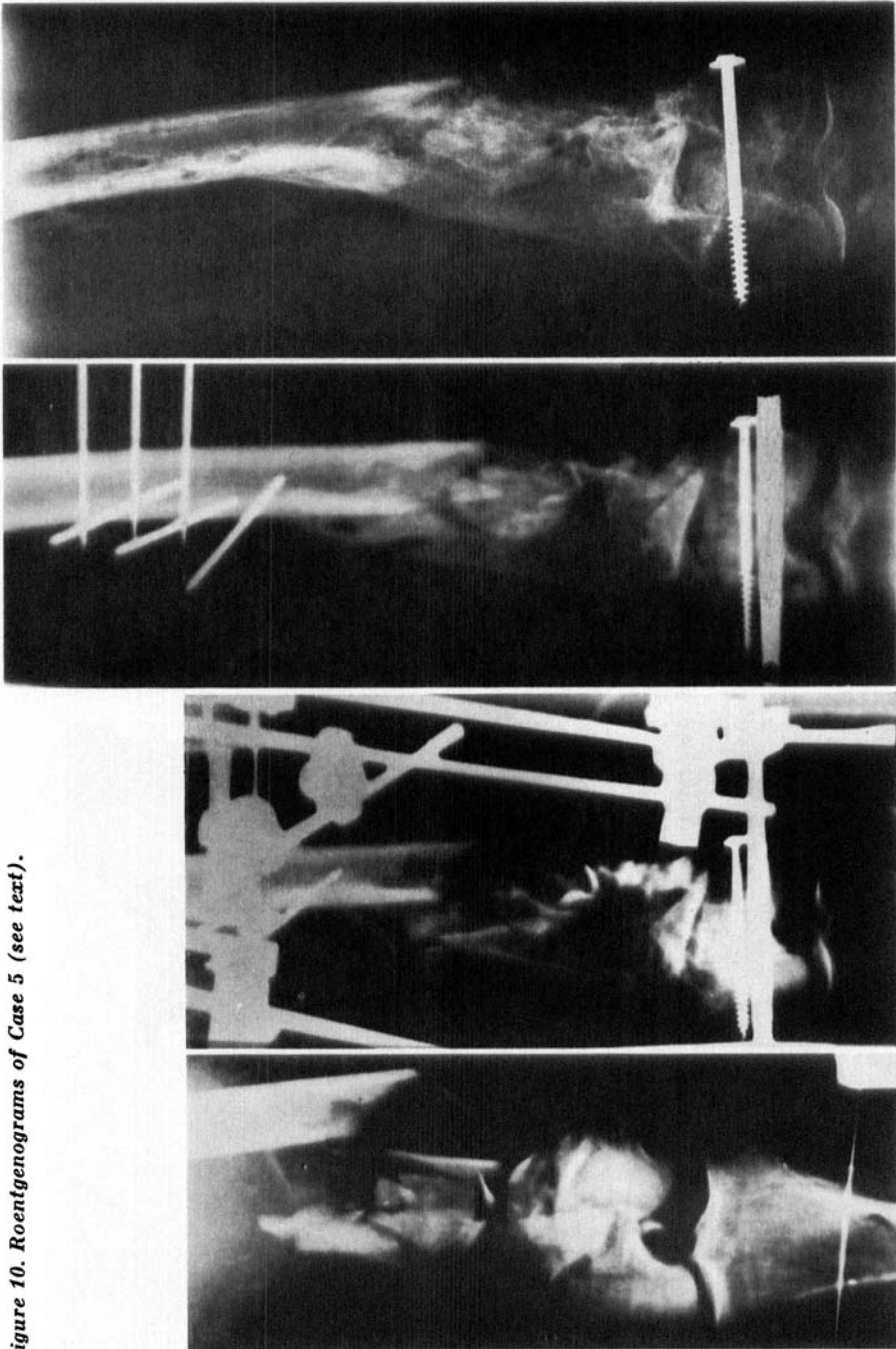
Roentgenograms of Case 5 (see text).
